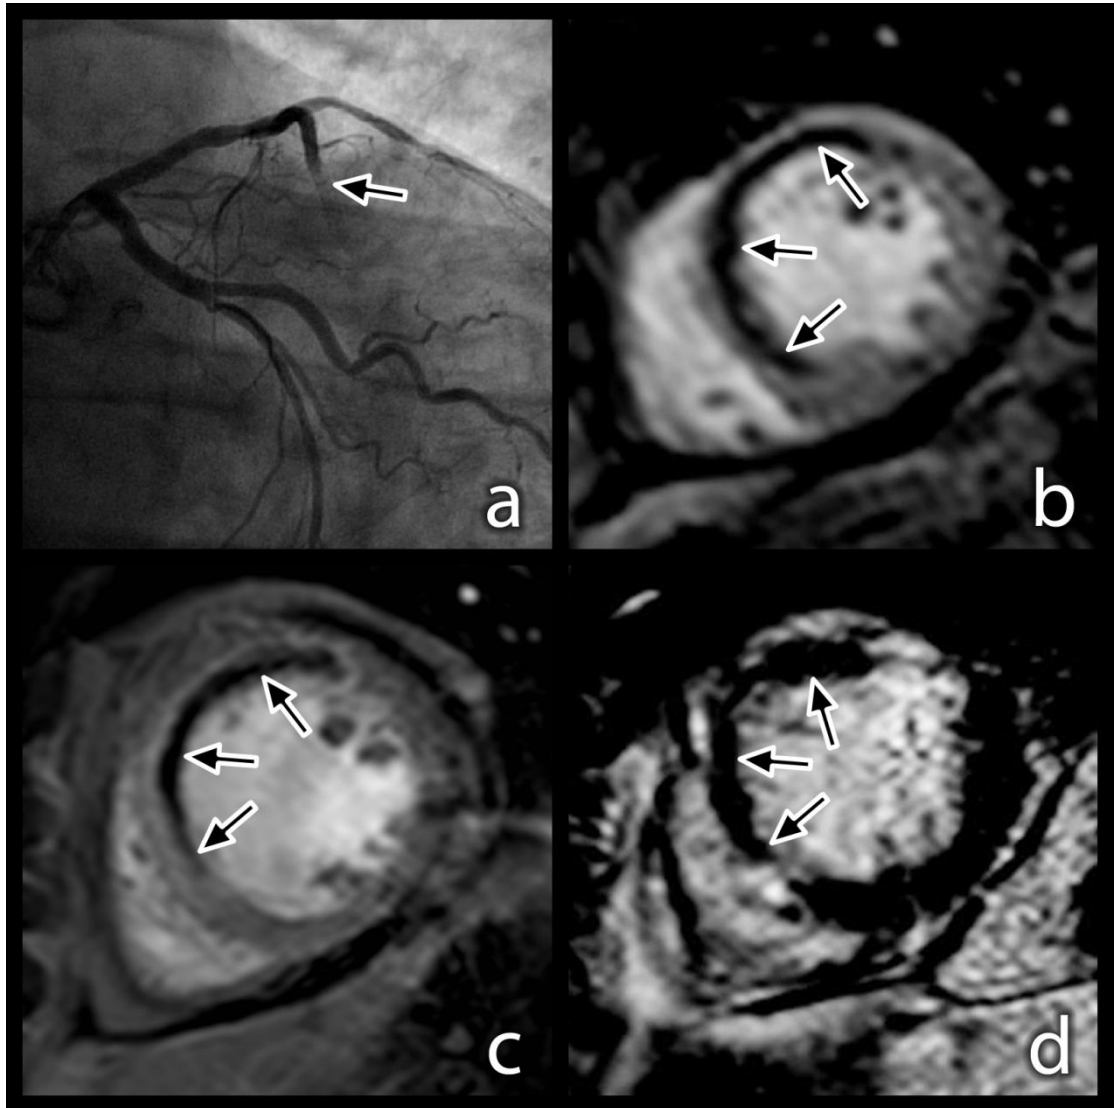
Microvascular obstruction following reperfusion to the left anterior descending coronary artery. No-reflow following revascularisation is seen on X-ray coronary angiography (Panel a). Corresponding anterior territory hypoperfusion is seen on first pass perfusion CMR (Panel b), and a hypointense infarct core is seen on early gadolinium enhancement (Panel c) and late gadolinium enhancement (Panel d).
